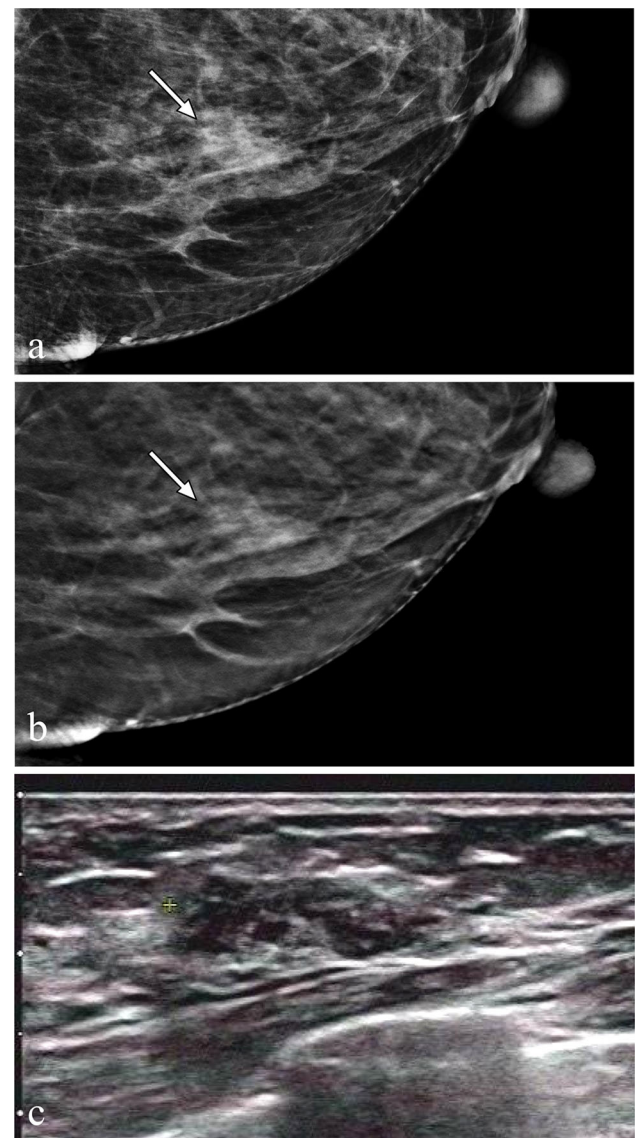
Mammography and ultrasonography images in a 59-year-old woman with ductal carcinoma in situ in the *left* breast. a Mediobasal oblique DM image. b Mediobasal oblique DBT image. c US image. The lesion was detected by DBT and DM (b, a, arrow) in which the fibroglandular was considered for the diagnosis and the reader scores were 3. But on US c, reader scores for the study were 4A
